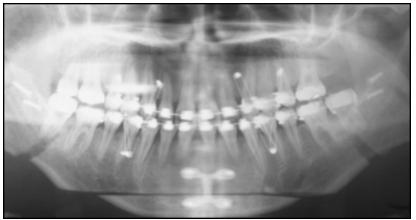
Postoperative radiographs showing six miniscrews inserted for intermaxillary fixation.
